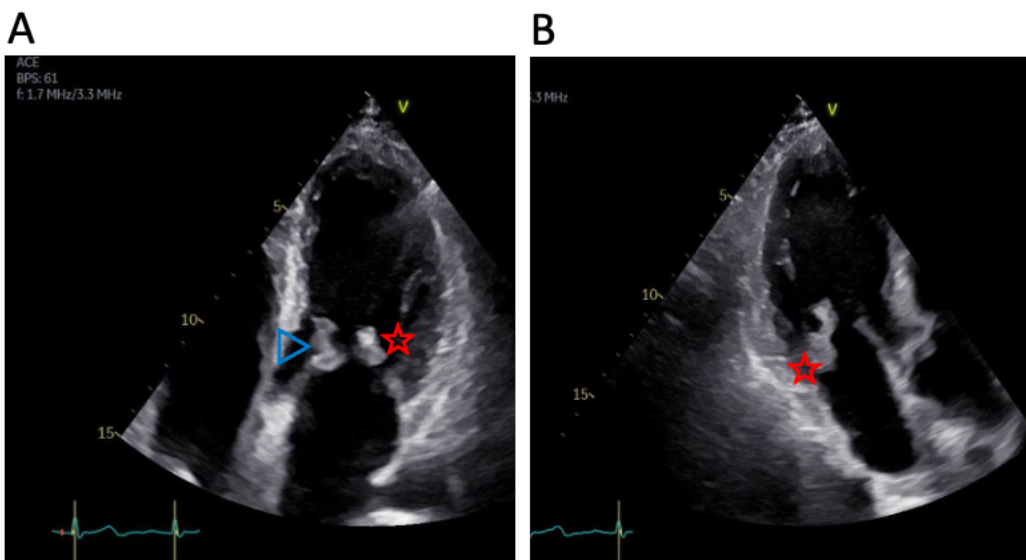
Transthoracic echocardiography showing vegetation on posterior (red star) and anterior mitral leaflet (blue arrow) in 4-chamber view (A) and 3-chamber view (B)
